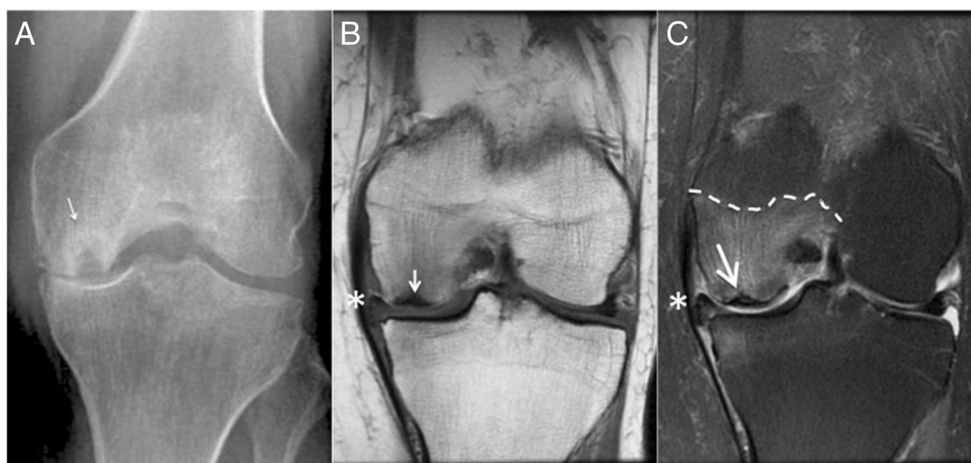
a A 67-year-old female with knee pain. AP radiograph demonstrates radiolucent ovoid lesion with sclerotic halo within the medial femoral condyle (*white arrow*). b An 84-year-old female with left knee pain after a fall. Coronal T1-weighted image demonstrates a low signal intensity focus beneath the articular surface of the medial femoral condyle (*white arrow*). Abnormal intrinsic signal and extrusion
